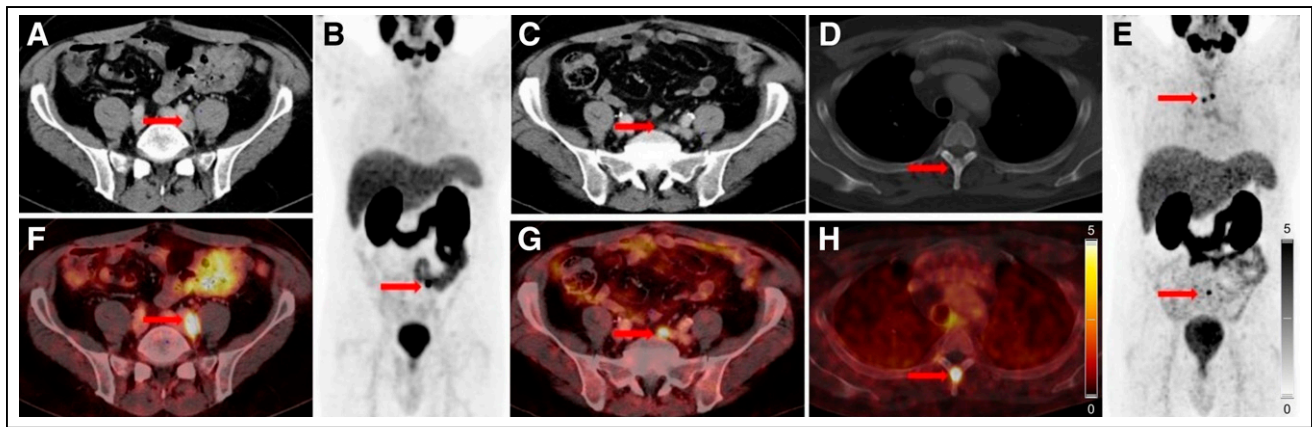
61-y-old patient presenting with BCR with PSA level of 1.35 ng/mL. (A–C) PSMA PET/CT scan showed 2 lymph node metastases adjacent to left common iliac artery (arrows). After RGS, PSA nadir was 0.09 ng/mL, and 18 mo later, PSA level increased to 3.25 ng/mL. (D–H) Second PSMA PET/CT scan showed lymph node metastases adjacent to the left common iliac artery, as well as new bone metastases (T4, fourth rib on left).
